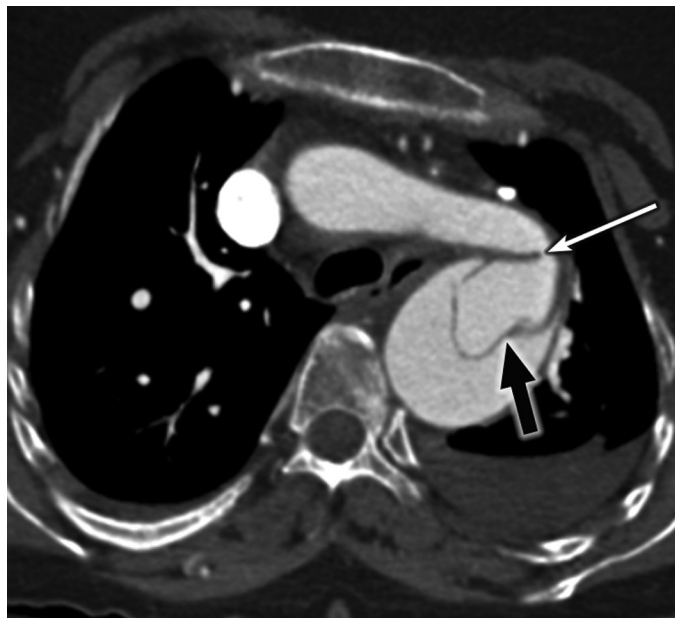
FIGURE e57-2 Contrast-enhanced CT scan of a 47-year-old woman with TS demonstrating an elongated aortic arch, coarctation of the aorta (*white arrow*), dilated proximal descending aorta, and acute type B aortic dissection (*black arrow*).
